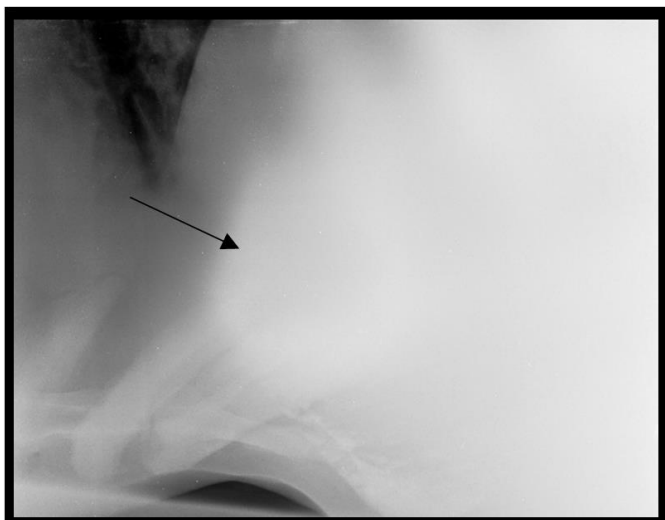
Radiograph showing radio-opaque body in reticulum (plastic)
